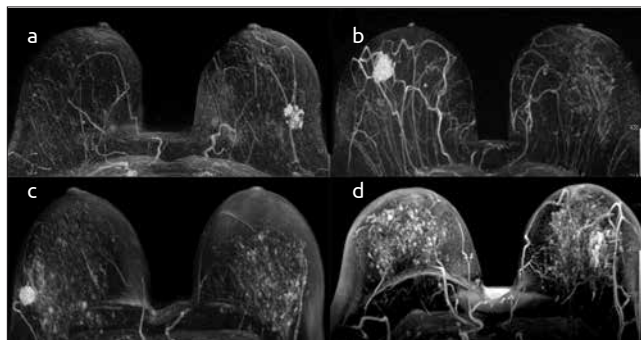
a-d. Axial fat-suppressed T1-weighted dynamic, contrast-enhanced MR images show different breast tissues with minimal (a), mild (b), moderate (c), and marked (d) BPE
